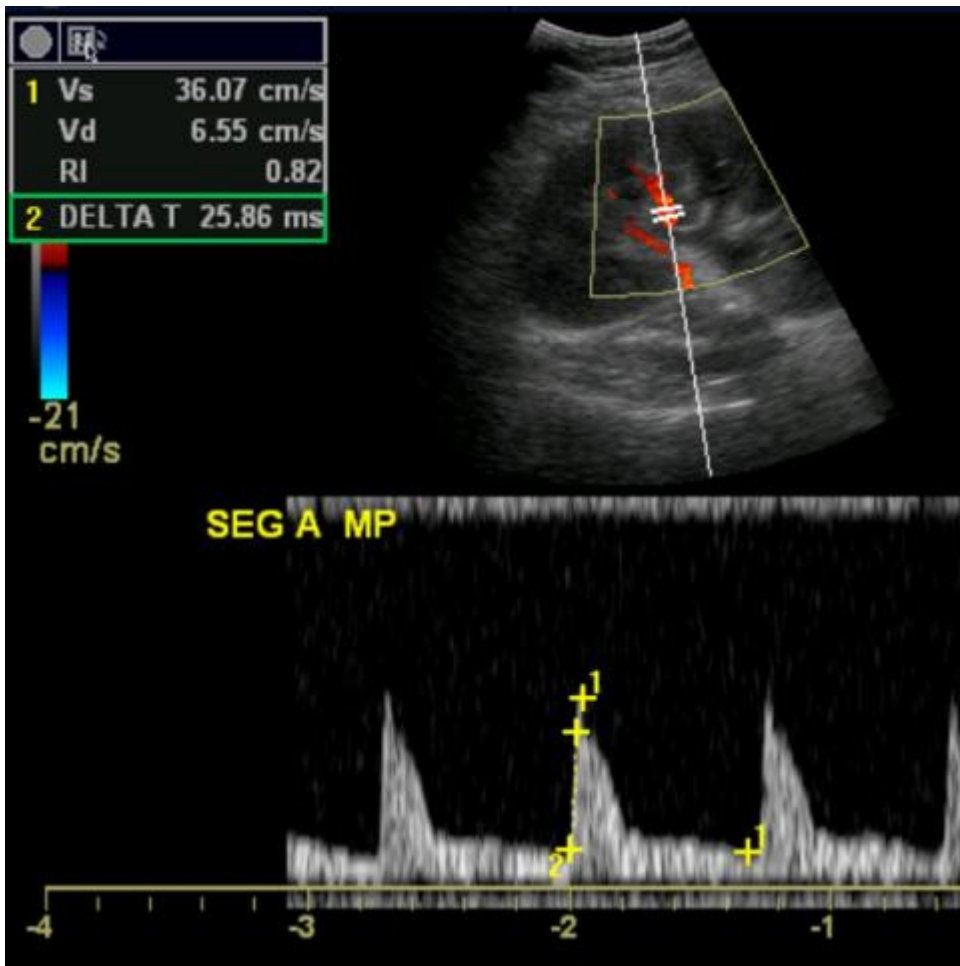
Acute rejection. Spectral Doppler image of a segmental artery reveals a mildly increased resistive index due to parenchymal edema. Biopsy indicated acute rejection.
